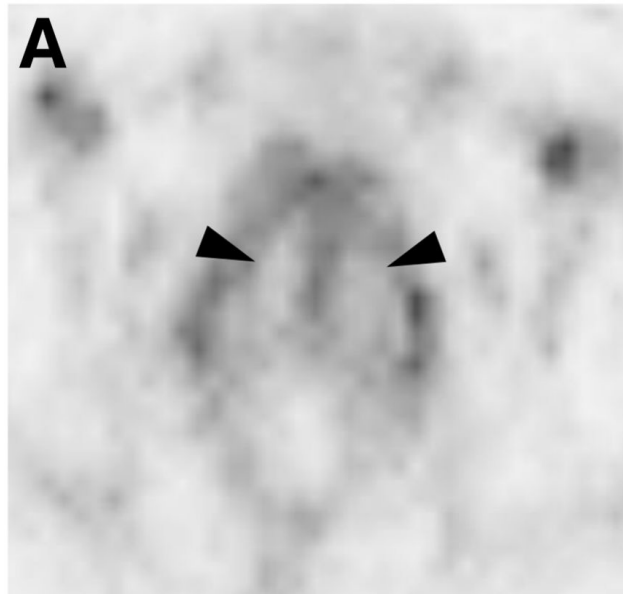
Advantage of small field-of-view (FOV) DWI. 66 year-old patient with PSA 6.1. 351 ng/ml. A: T2WI shows a lesion in the right anterior mid transition zone (arrow). Restricted. 352 diffusion is demonstrated with high signal on the b-1400 DWI (B, D) and corresponding low. 353 signal on the ADC maps (C, E), with small FOV imaging showing improved signal-to-noise 354 ratio and increased lesion conspicuity (D, E), compared to standard DWI (B, C).
